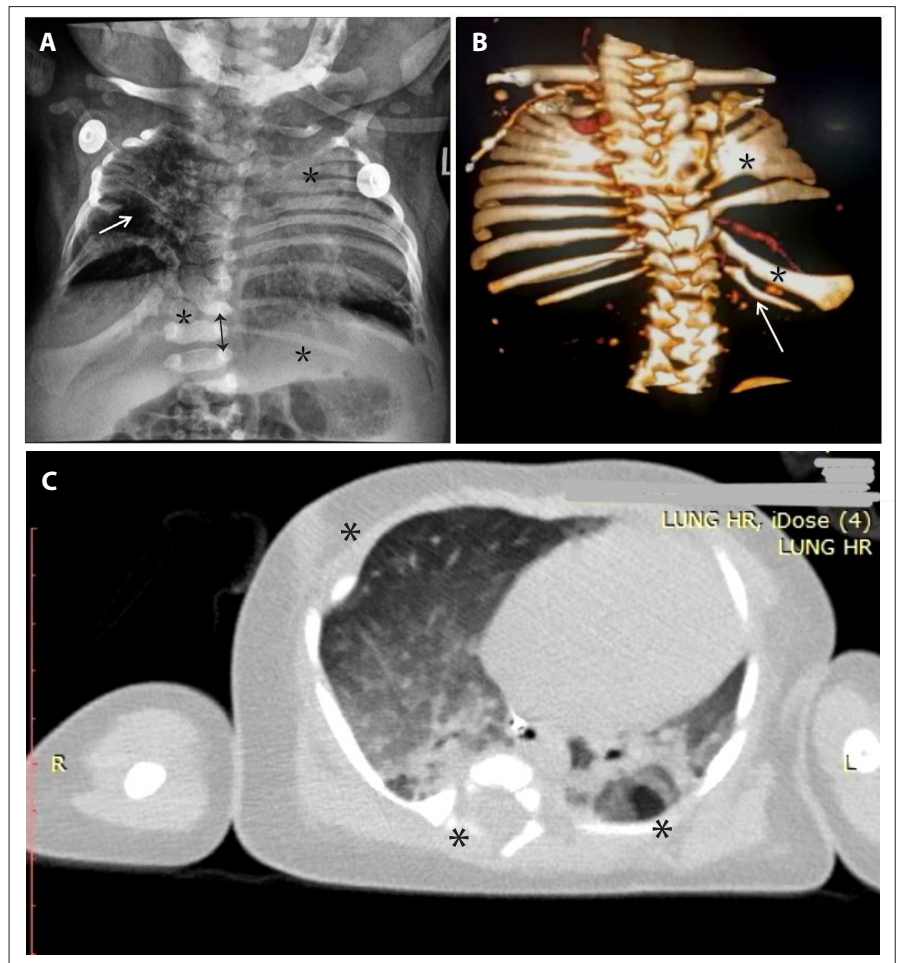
(A) Chest radiograph. Arrow: rib deformities, absent posterior lower ribs and reduced right lung volume. Top asterisk: fusion of ribs and deformed vertebrae. Bottom asterisk: rib hypoplasia, which is bilateral. Spinal asterisk: hemivertebrae and mild scoliosis. Left vertebral line: pedicular prominence ('tramline' sign). Left lung opacification is also noted. (B) Posterior view of the three-dimensional reconstruction of the spine and ribs, showing a 'crab-like' ribcage. Absent 1st ribs bilaterally. Top right asterisk: fused posterior ribs bilaterally and fused vertebral bodies. Bottom right asterisk: fused ribs 8 and 11. Arrow: hypoplastic 12th rib bilaterally. Scoliosis is better visualised. (C) Computed tomography scan of the chest. Left asterisk: posterior bullae of the lungs with interstitial and cystic lesions in the mid- and upper zones, features of pneumonia/pneumonitis and possible pulmonary malformations. The large airways are normal. Right top asterisk: absent ribs. Right bottom asterisk: spina bifida.
